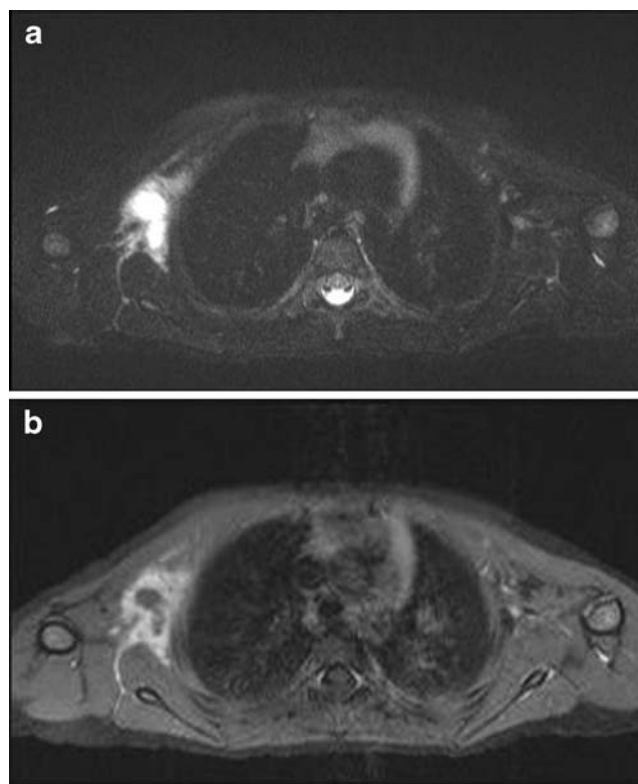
Chest wall abscess. A 5-year-old boy was referred to our hospital with weakness of the upper right arm, local pain in the shoulder and fever. Radiography and US of the shoulder were normal. An MR study was performed. (a) Axial T2-W image with fat saturation (FS) at the level of the upper thorax shows a hyperintense lesion in the right axilla with infiltration of the soft tissues. (b) Axial T1-W FS image after gadolinium administration shows peripheral enhancement. The findings are consistent with infectious lymphadenitis with a central abscess. Conservative antibiotic treatment was successful in this boy
